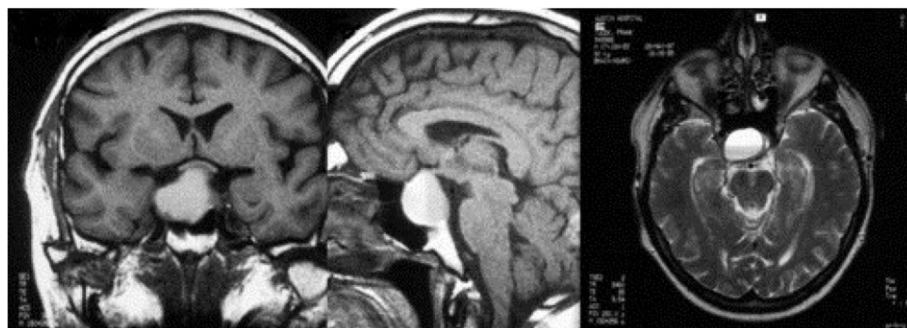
Axial and sagittal T1-weighted and transverse T2-weighted MRIs showing a large hemorrhage into the pituitary gland. Courtesy of G. Fitt.
